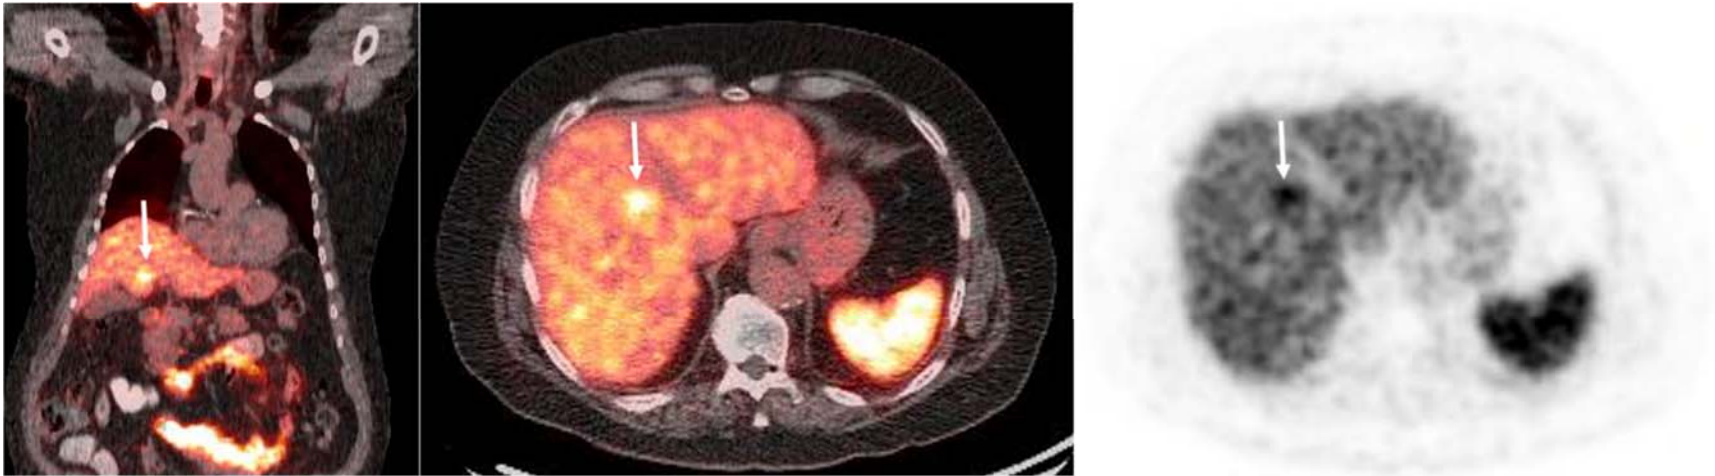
Case 4: Focal hepatic segment IVb radiotracer avidity seen on the ^{68}Ga -PSMA PET/CT imaging of a 74-year-old man with biochemical recurrence of PCa (Gleason 4+5) following radical prostatectomy. PSA was 0.57 ng/mL. A left inferior pubic ramus lesion suspicious for recurrence was seen on PET/CT (not shown). No abnormality in the liver parenchyma was seen on the ceCT (not shown) done two weeks prior to the PET/CT. An aberrant hepatic vasculature was also not identified. A case of focal intense ^{68}Ga -PSMA uptake in hepatic segment II has been previously reported in the literature.⁴ This focal avidity was presumably due to an intra-hepatic vascular malformation and is different from the cases herein presented, which are located in hepatic segment IVb, with at least two associated with an aberrant extra-hepatic vasculature. Muñoz and Fraum recently reported a case of focal avidity on PSMA PET in hepatic segment IVb.⁵ Similar to our cases, they also demonstrated an anomalous vessel piercing the hepatic capsule and entering hepatic segment IV. The hepatic vascular anatomy is unique for its two inflow systems, the portal venous and the hepatic arterial inflow. In some individuals, a third inflow system occurs as a normal variant. The origin of anomalous vascular supply to hepatic segment IV is highly variable.⁶ The third inflow system may cause focal contrast enhancement or radiotracer uptake on imaging, which can be misinterpreted as a neoplastic entity.⁷ ^{18}F -FDG uptake in the liver secondary to vascular obstruction is well known.⁸⁻¹⁰ No vascular obstruction was identified in any of the presented cases. These cases of artifactual focal hepatic avidity on PSMA PET are useful to raise awareness of their likelihood, and their potential to cause image misinterpretation leading to unwanted prostate cancer treatment escalation or denying patients therapy with curative intent. In this era of the application of PSMA PET imaging in hepatocellular carcinoma imaging,^{11,12} awareness of this potential pitfall is vital for the accurate quantification of hepatic tumor burden.
